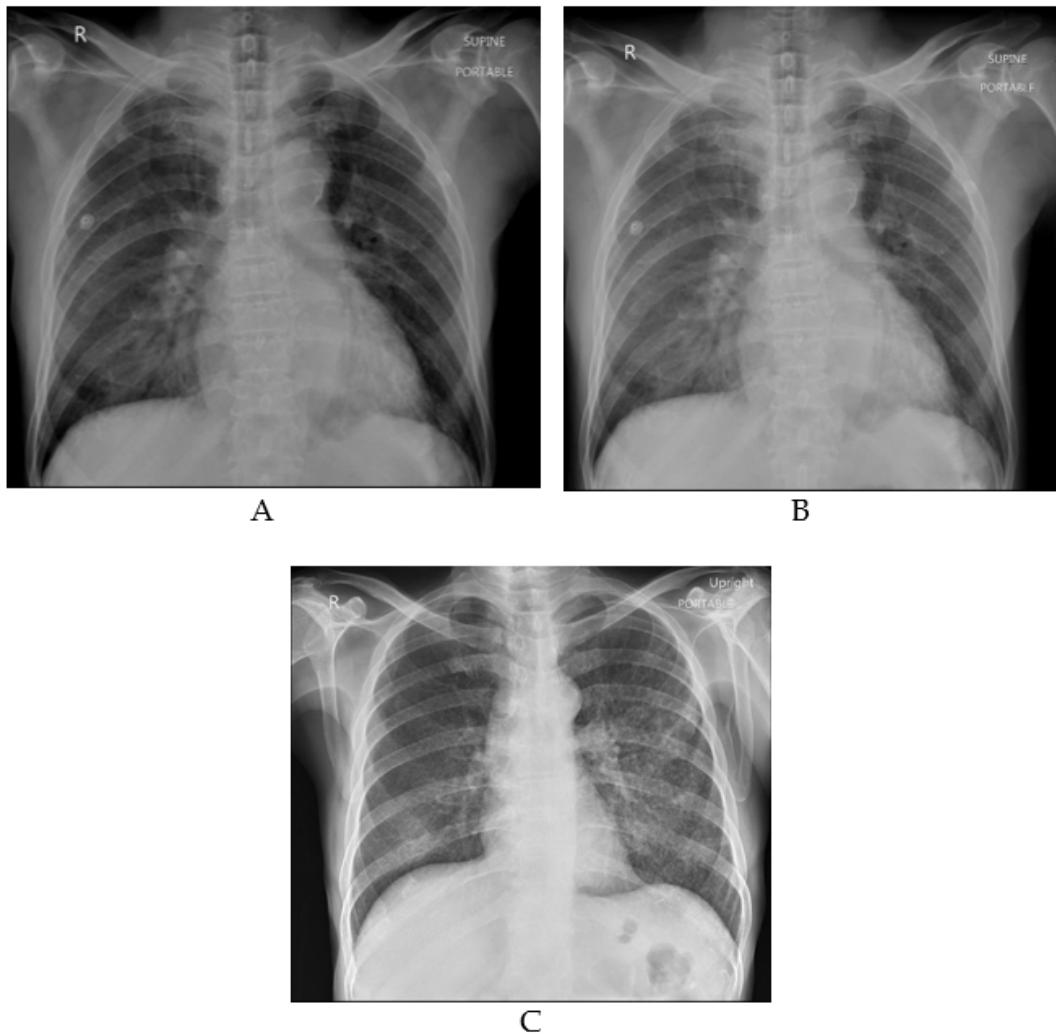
Chest radiographs of Patient 1 (A and B) and Patient 2 (C)
